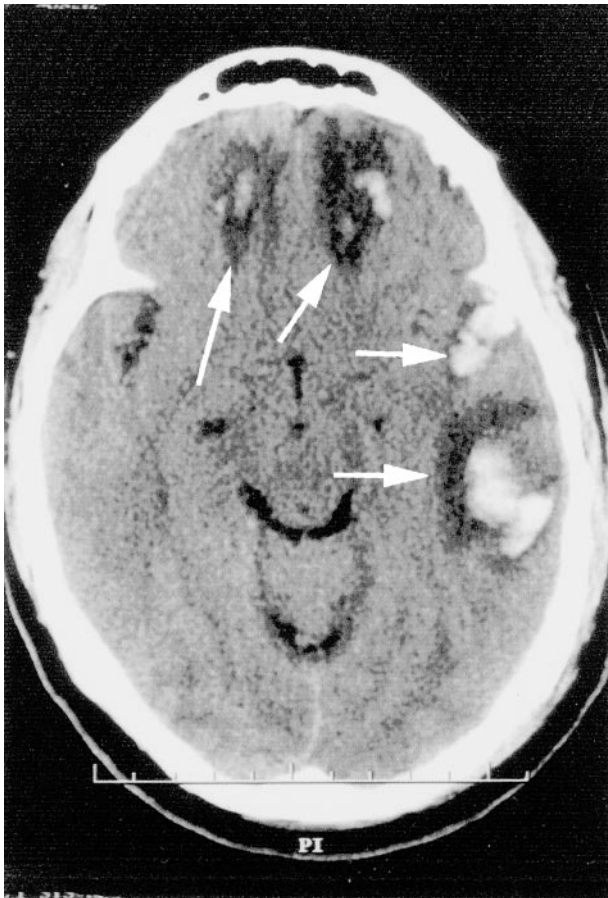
CT scan demonstrating multiple hemorrhagic contusions in the bifrontal region, and left temporal and parietal region with surrounding edema (arrows).
